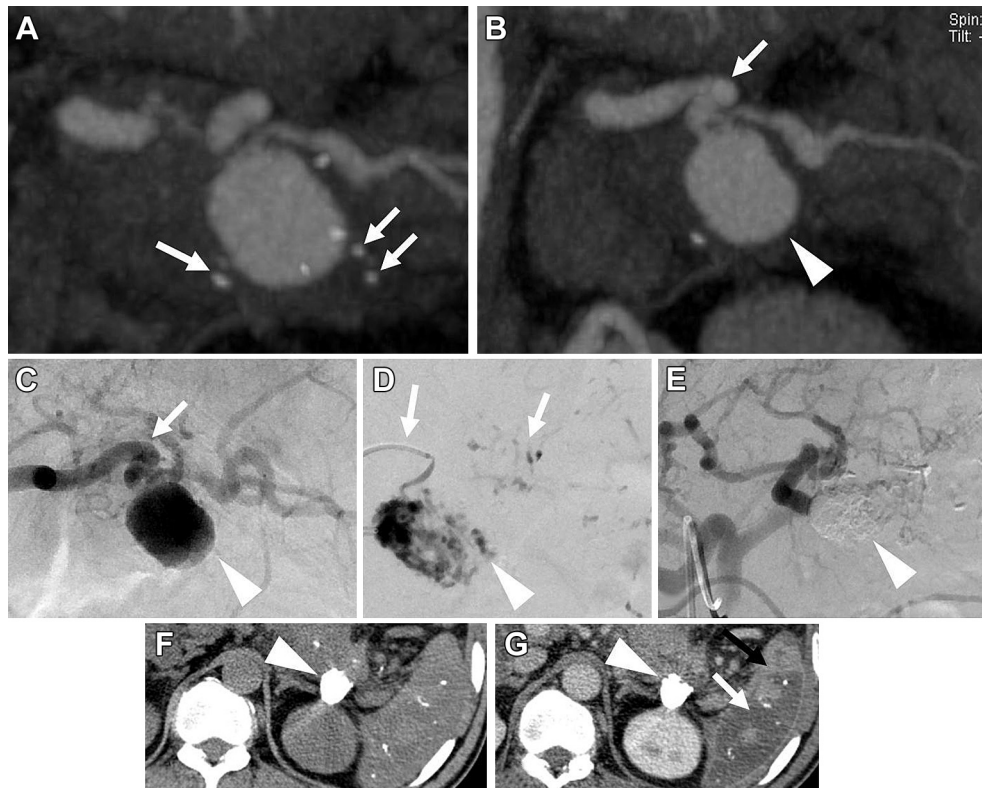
A 53-year-old male with chronic pancreatitis presented with abdominal pain. Contrast-enhanced computed tomography (CT) and celiac digital subtraction angiography shows multiple intraparenchymal calcifications (A, arrows) and pseudoaneurysm (B,C arrowhead) arising from the distal splenic artery (B,C arrow). (D) As distal access was not achieved, direct intra-arterial *N*-butyl cyanoacrylate injection was performed with the microcatheter tip just proximal to the pseudoaneurysm (arrow). Note spillover of glue into the distal splenic artery branches (small arrow). Post embolization DSA (E) and CT (F) shows glue cast (arrow head). (G) Contrast-enhanced CT 5 days later shows no reperfusion of pseudoaneurysm (arrow head) and multiple splenic infarcts (arrow).
